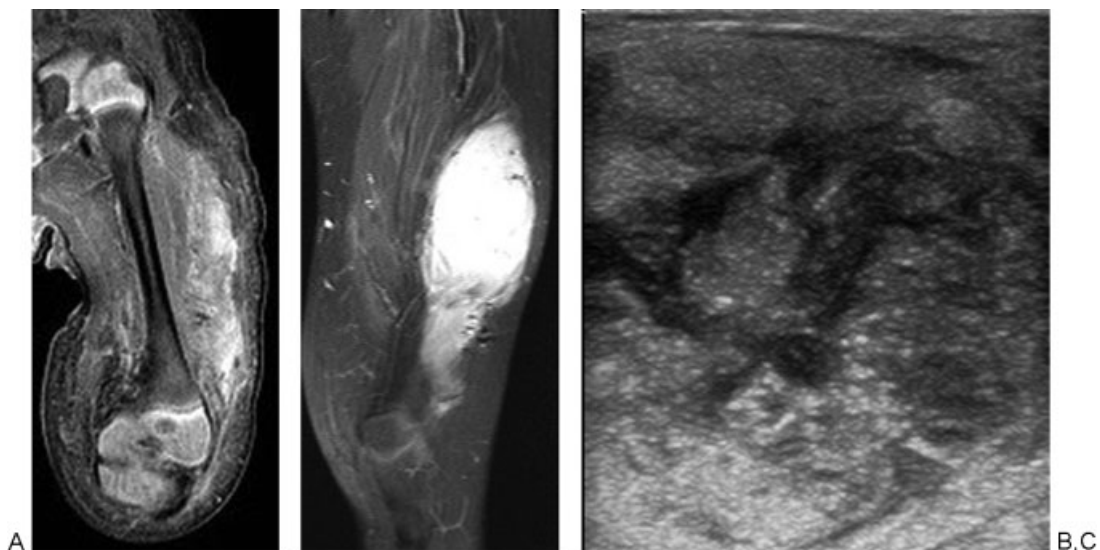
A 1-month-old baby with thigh mass. (A) MRI with diffuse vastus lateralis tissue thickening. A biopsy was performed, and the diagnosis of diffuse infantile fibromatosis was made. No therapy was undertaken, and the lesion became more discreet over time. (B) MRI at age 7 demonstrating a symptomatic enlargement of the mass. At this point, the family opted for intralesional injection treatment. (C) Ultrasound image during 50% acetic acid injection with immediate posttreatment fluid leakage around mass. Abdominal pain and nausea 3 days later required hospitalization for acute kidney injury from tumor lysis or acetic acid–induced crystal/cast nephropathy. Subsequent repeat biopsy showed a fibrosarcoma with tumor dedifferentiation. MRI, magnetic resonance imaging.
